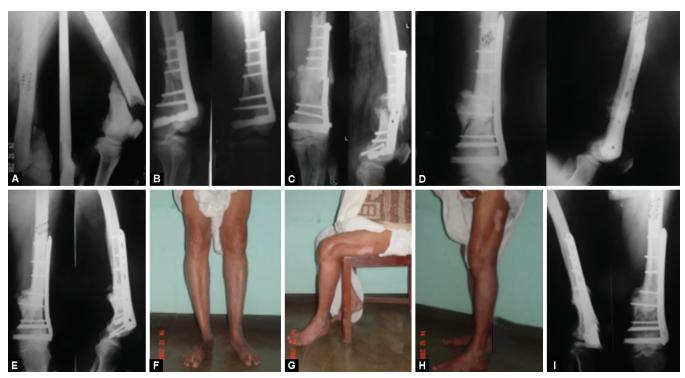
to G: A 62-year-old female, 33-A3, had surgery elsewhere (3 times before; primary fixation followed by bone grafting 2 times), (A) Anteroposterior (AP) and lateral radiographs showing non-union at her fracture site with implant failure; (B) The AP and lateral radiographs after revision fixation with bone grafting was done with compression achieved *via* Muller's device and lag screw; (C and D) Radiographs showing intertrochanteric fracture with subtrochanteric extension after 1.5 years, and managed by PFN was done; (E to G) Radiographs and clinical photographs showing union and satisfactory outcome after 31 months
